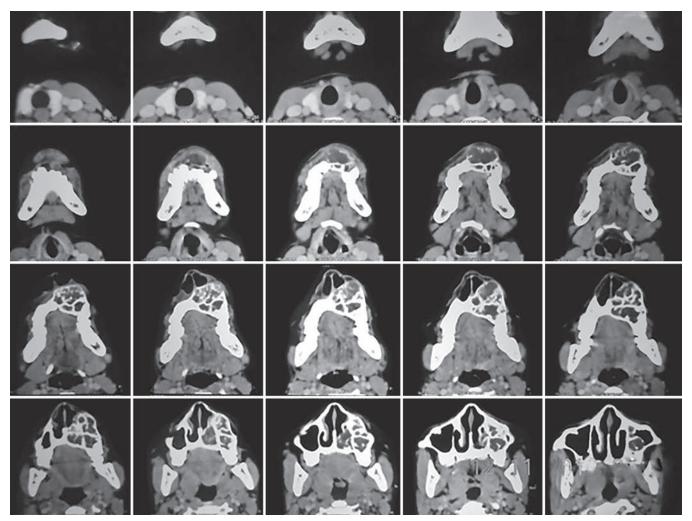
Computed tomography scan showing the extent
